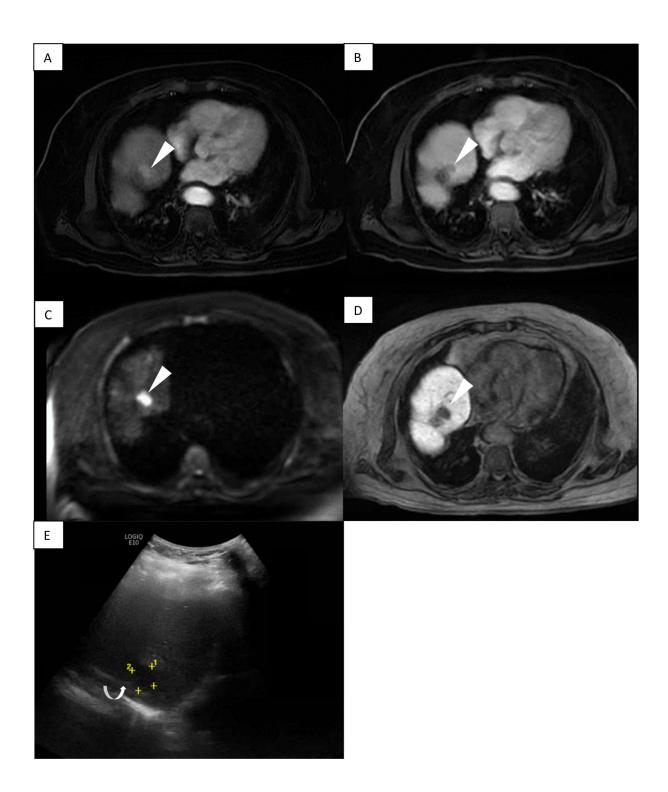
Partially visible nodule on ultrasound
